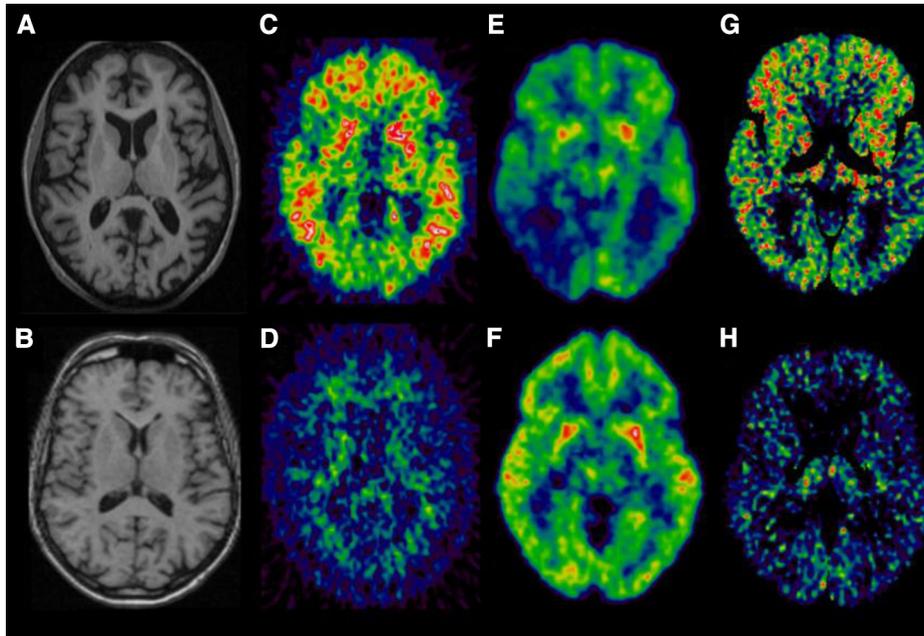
Representative transversal image sections from a control subject and an AD patient. MRI scan in an AD patient (A) and a control subject (B).  $[^{11}\text{C}]\text{PiB}$ -PET scan in AD (C) and control (D) showing increased uptake of in the cortical areas of the AD patient. FDG-PET scan in AD (E) and control (F) subjects indicating hypometabolism in AD.  $[^{11}\text{C}]\text{PK11195}$  PET scans in AD (G) and control (H) subjects revealing microglial activation in AD.
